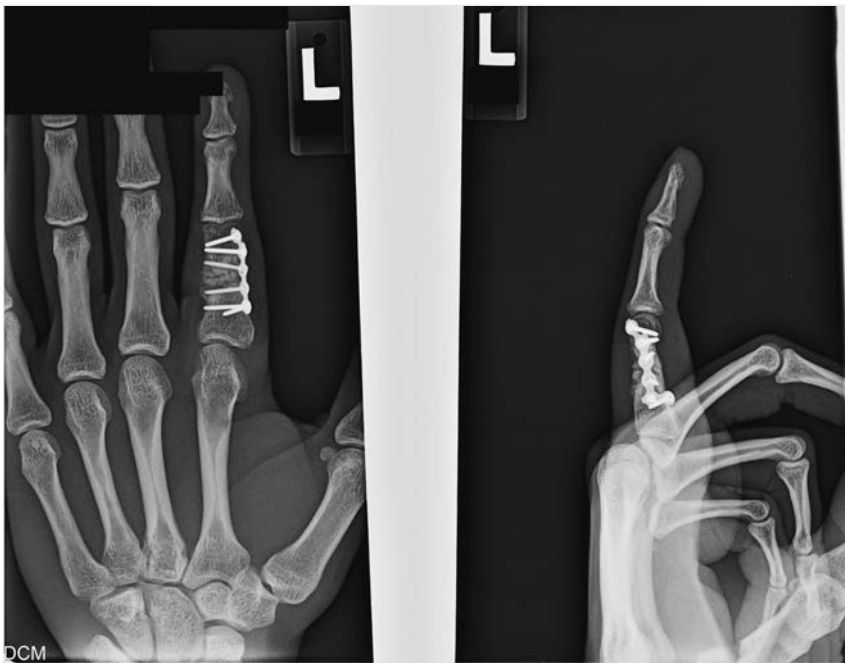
Three months postoperative radiographs reveal continued bone growth without deformity.
